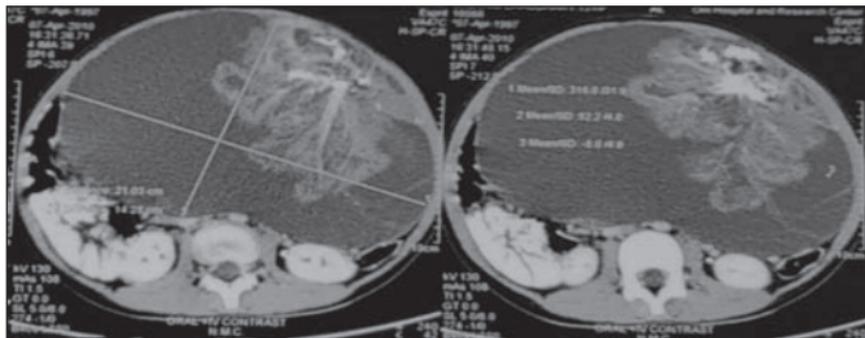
CT images of the cystic lesion
